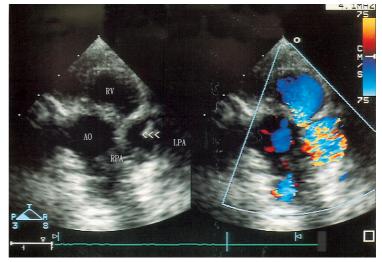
Postoperative echocardiography demonstrates mobile bicuspid leaflets (arrowheads) with mild pulmonary stenosis and regurgitation. RV = right ventricle; AO = aorta; RPA = right pulmonary artery; LPA = left pulmonary artery.
